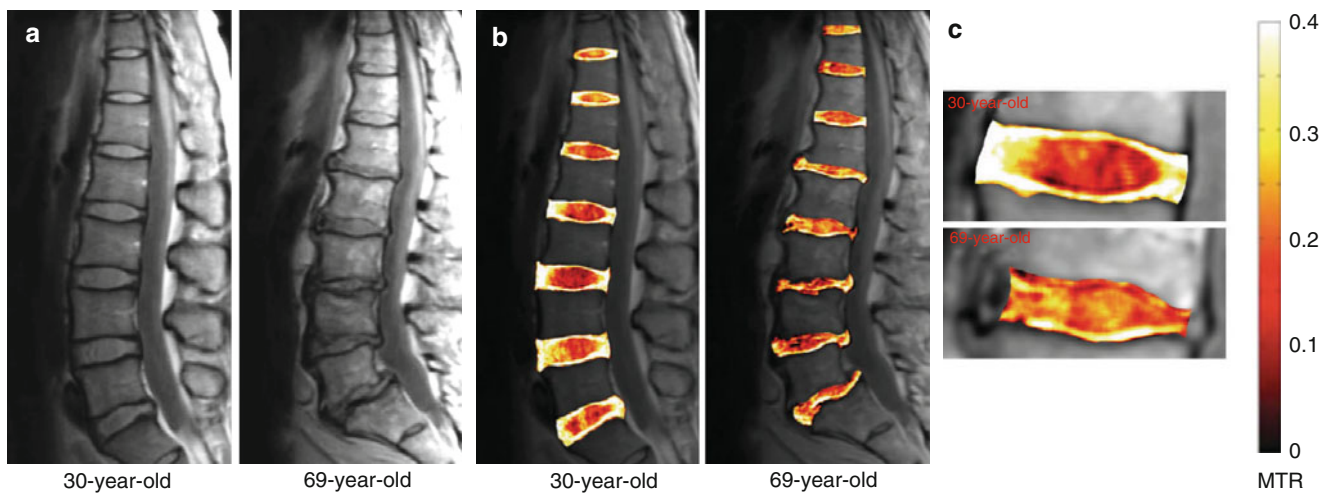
(a) Proton-density MRI of a 30-year-old healthy and a 69-year-old asymptomatic subject. (b) MTR map (in color), (c) MTR maps of the L3/L2 disc (Wang et al. 2010c)
